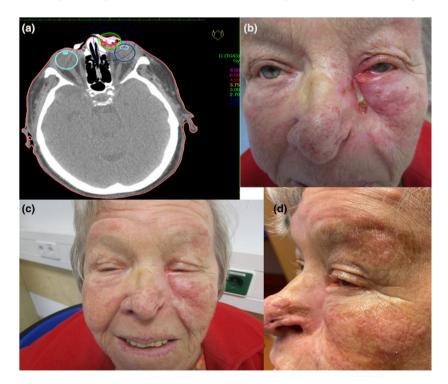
An 86-year-old patient with a basal cell cancer in the left corner of the eye. (a) Planning CT of the patient depicting the target volume (red) and critical structures (both eyeballs and lenses) in axial view. Prescription dose was 33.0 Gy to a target of 2.99 ml in oncedaily fractional doses of 3.0 Gy delivered using seven embedded applicators. The 1.5 Gy isodose per fraction is encompassing the medial part of the eyeball resulting in a cumulative dose of 16.5 Gy to this part of the eye. (b) Conjunctivitis grade 2 on treatment day 14 as acute adverse event of the radiation dose exposure to the eyeball; (c, d) follow-up on day 70 (c) and on day 127 (d) with complete resolution of the radiation-induced toxicity
